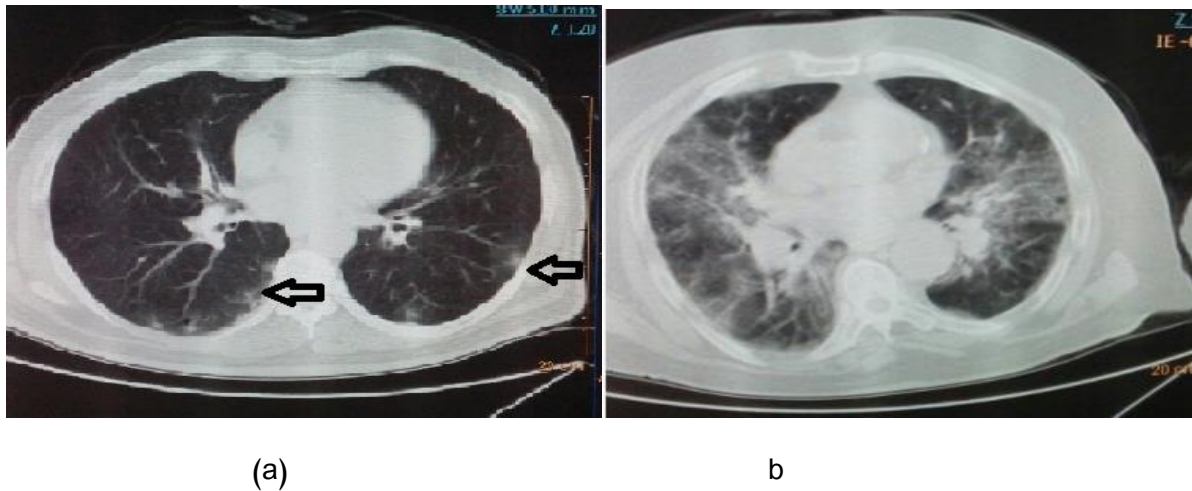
(a) Axial thin sections of CT chest scan show mild GGO involving bilateral peripheral upper lobes (b) Axial sections show diffuse crazy paving pattern with areas of peripheral consolidations indicating severe disease and classified under severity cases .
